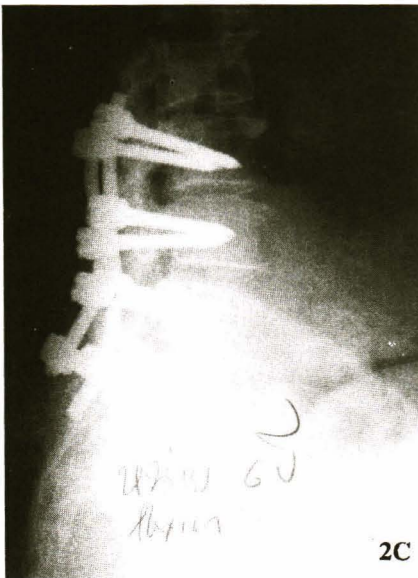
(A-D). The 6th year follow-up X-ray pictures of 72 years old woman, who was performed decompressive laminectomy and PL fusion with laminospinous process bone graft.
